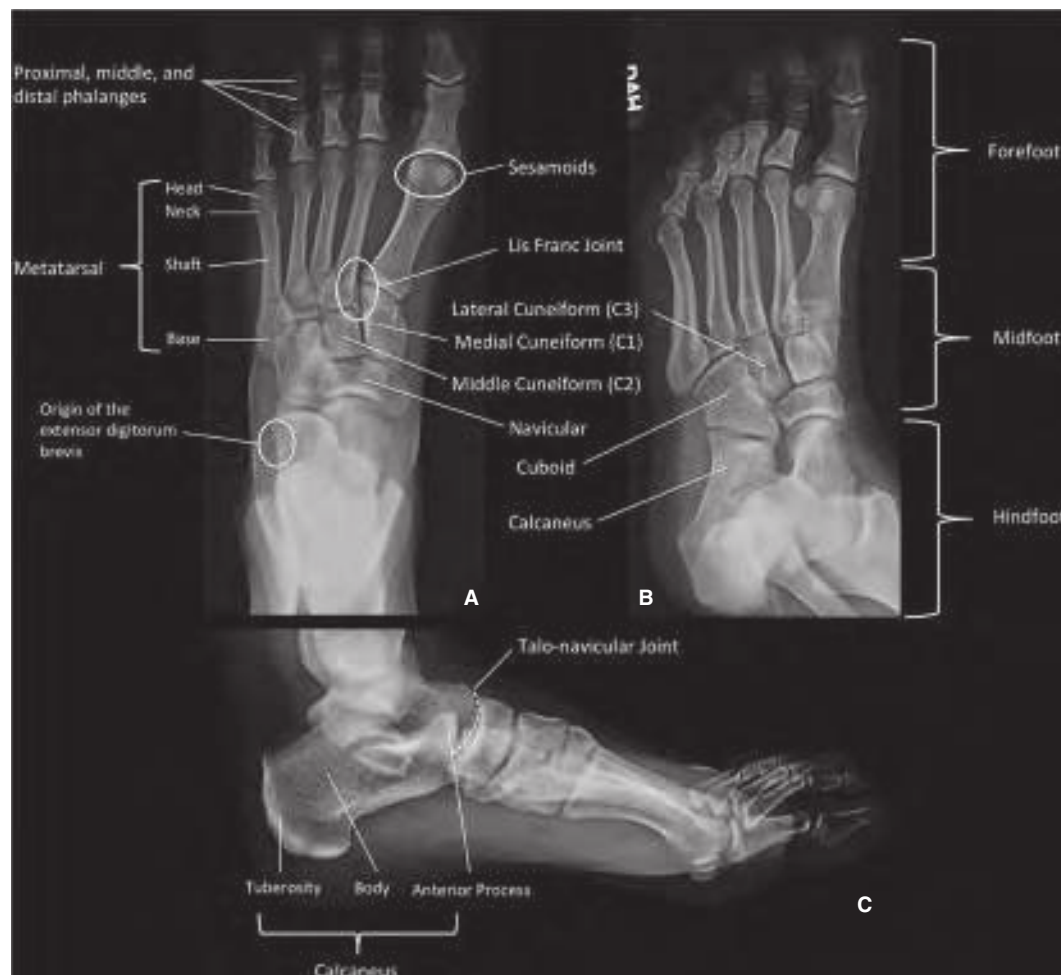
Foot radiographic anatomy. A. Anteroposterior view. B. Oblique view. C. Lateral view. (Used with permission from reference 1.)
